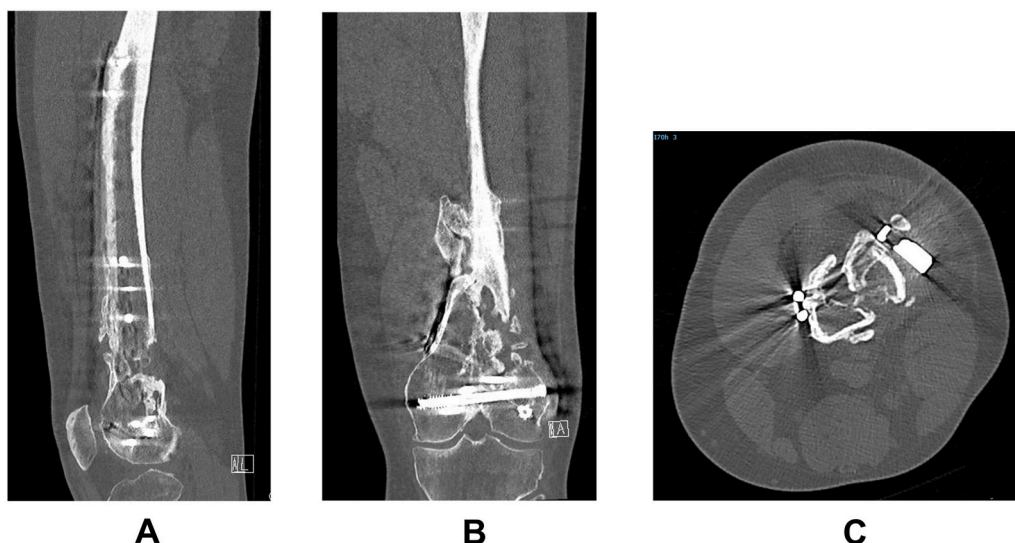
Panel A: Sagittal CT-view of left leg showing partial union.
